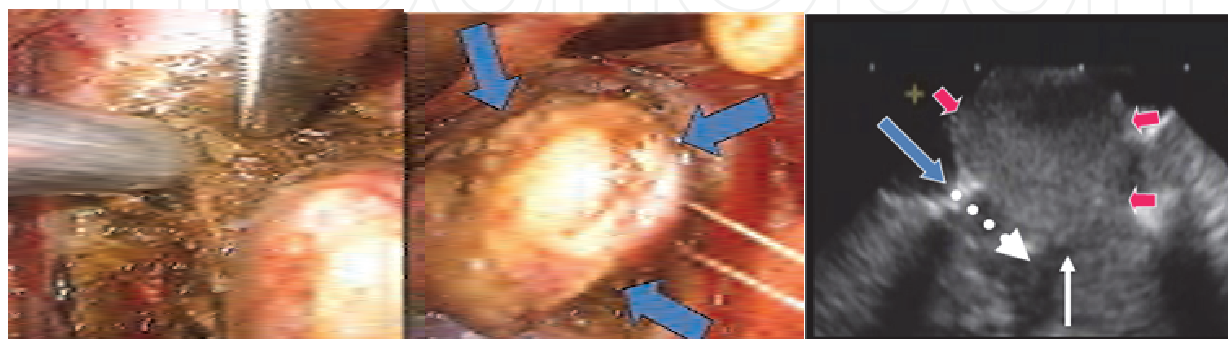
Ensuring that the normal tissue beneath the tumour is clear. Transection of the normal tissue beneath the tumour is performed under ultrasound guidance. White dotted arrow, the line to be transected; blue arrow, transected normal tissue; red arrow, tumour; white arrow, bottom of the tumour.
